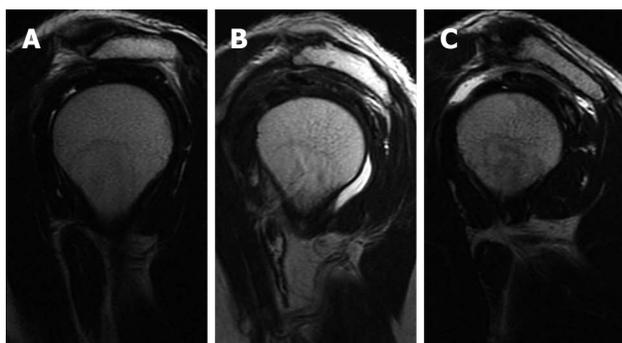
Acromion types. Sagittal oblique T2-weighted images of different patients showing type I flat acromion (A), type II concave under surface (B) and type III concave under surface with anterior hook (C).
